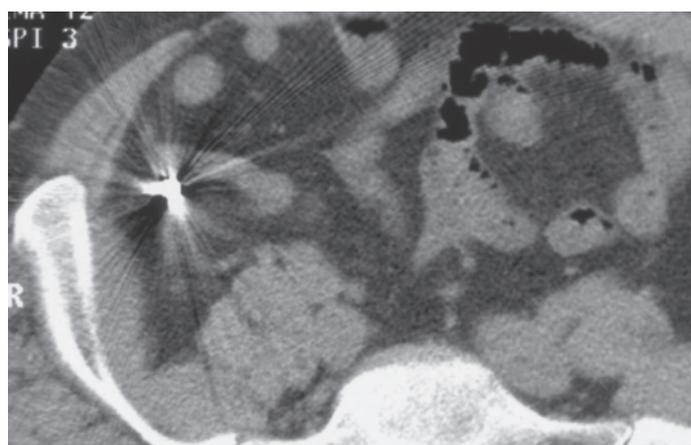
CT image of a solid metal foreign body and artifacts in the appendix region. This turned out to be a swallowed gold tooth.
